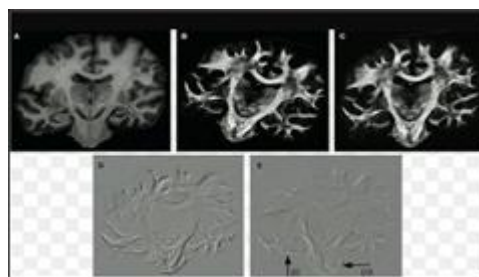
MRI Scan of Transformation.
